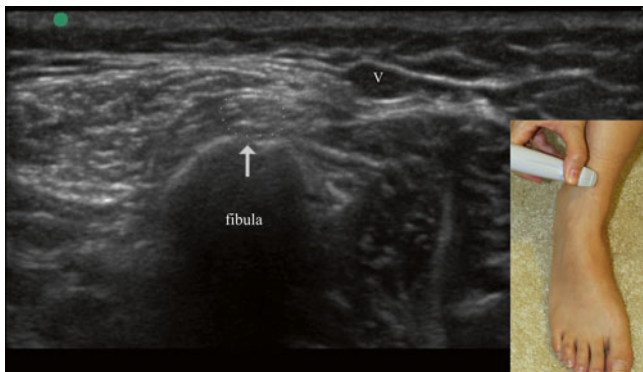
Ultrasound imaging of the distal superficial peroneal nerve at the flexor retinaculum. *V*= vein (Image courtesy of Andrea Trescot, MD)
